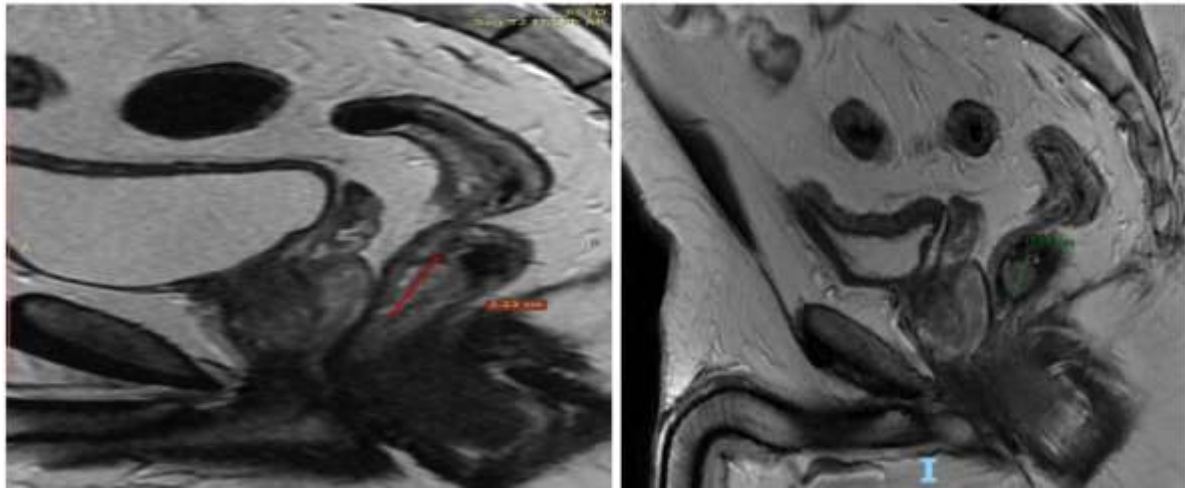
a) T2 sagittal view (06/04/2021) without procedures, only with ozone therapy, had already started ozone therapy before the first MRI; b) T2 sagittal plane (06/21/2021) after treatment with ozone therapy: Evident decrease in tumor size in this plane.
